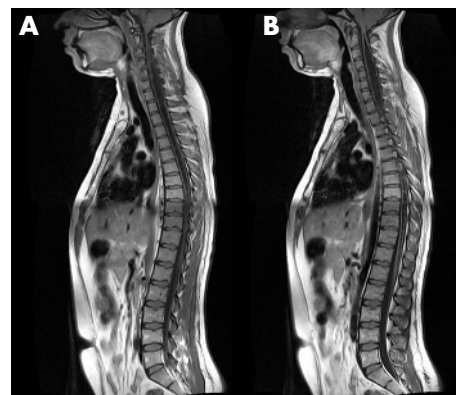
(A,B) Sagittal T1-weighted image of the whole spine shows the syrinx involving the entire cord.
